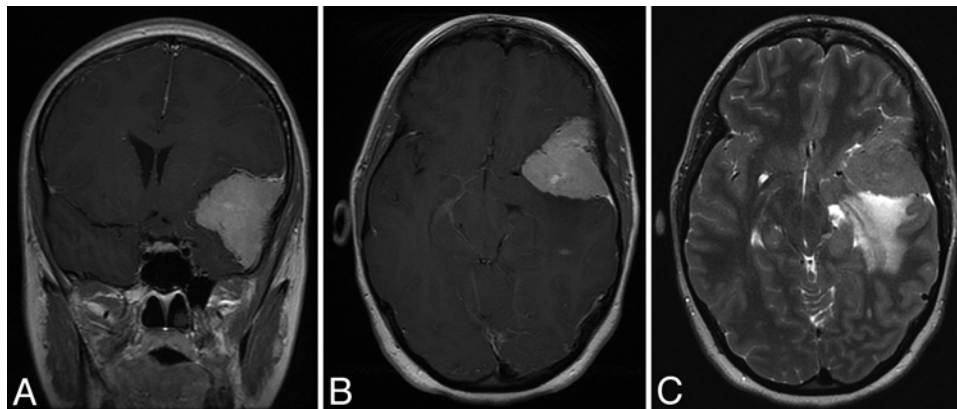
Case 2. Coronal (A) and axial (B) T1-weighted MR imaging with contrast enhancement and axial T2-weighted MR imaging (C) showing the presence of a large, left, lateral sphenoid wing meningioma. The lesion was 4.5 × 3.0 cm. The T2-weighted image demonstrates significant peritumoral edema. The large lesion (WHO Grade I meningioma) was surgically resected; 2 smaller contralateral lesions are being monitored with serial imaging.
